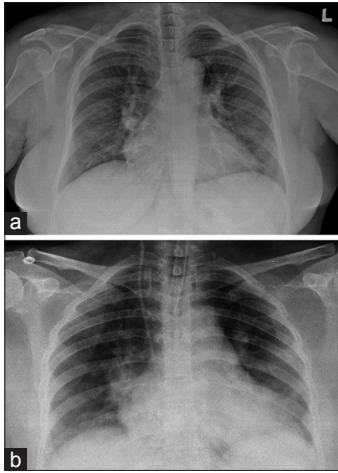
(a) Preoperative chest X-ray shows cardiomegaly and bilateral pulmonary plethora (b) chest X-ray after atrial septal defect device closure shows bilateral lung congestion in basal and hilar region
